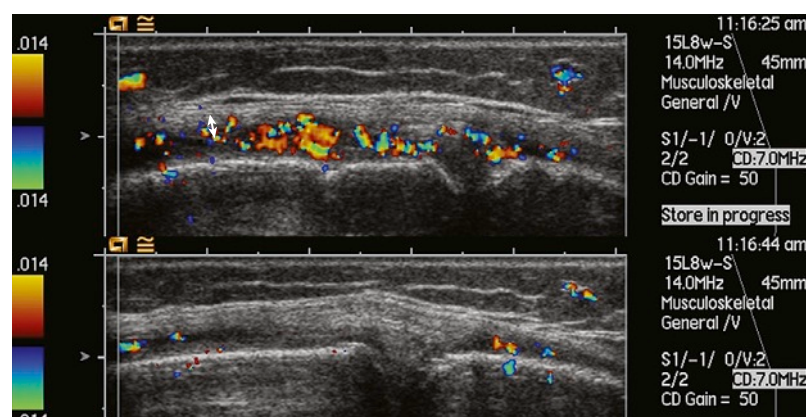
EFFECT OF TRANSDUCER PRESSURE. (Top) A longitudinal scan shows the medial recess of the knee joint in a patient with rheumatoid arthritis. There is thickening of the synovial membrane (double arrow) and marked hyperemia. Very light transducer pressure is used. (Bottom) When the transducer pressure is increased (subcutaneous fat and synovial membrane are visibly compressed), the resulting increased tissue pressure is higher than the blood pressure in most of the vessels. The result is markedly decreased Doppler activity.
